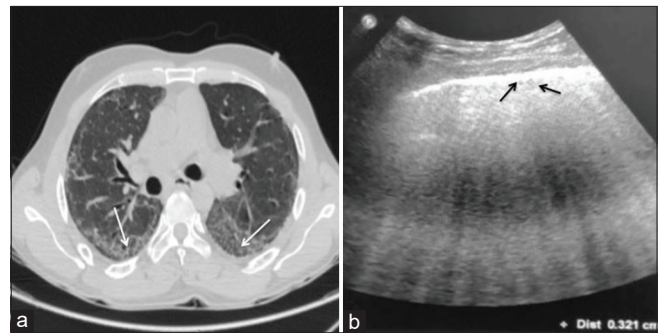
(a) Axial computerized tomography image of a patient with nonspecific interstitial pneumonia shows areas of bilateral ground-glass opacities (white arrows) (b) Corresponding ultrasonographic image performed using convex probe shows multiple closely spaced B-lines. The distance between B-lines is lesser ~3.2 mm (black arrows)
